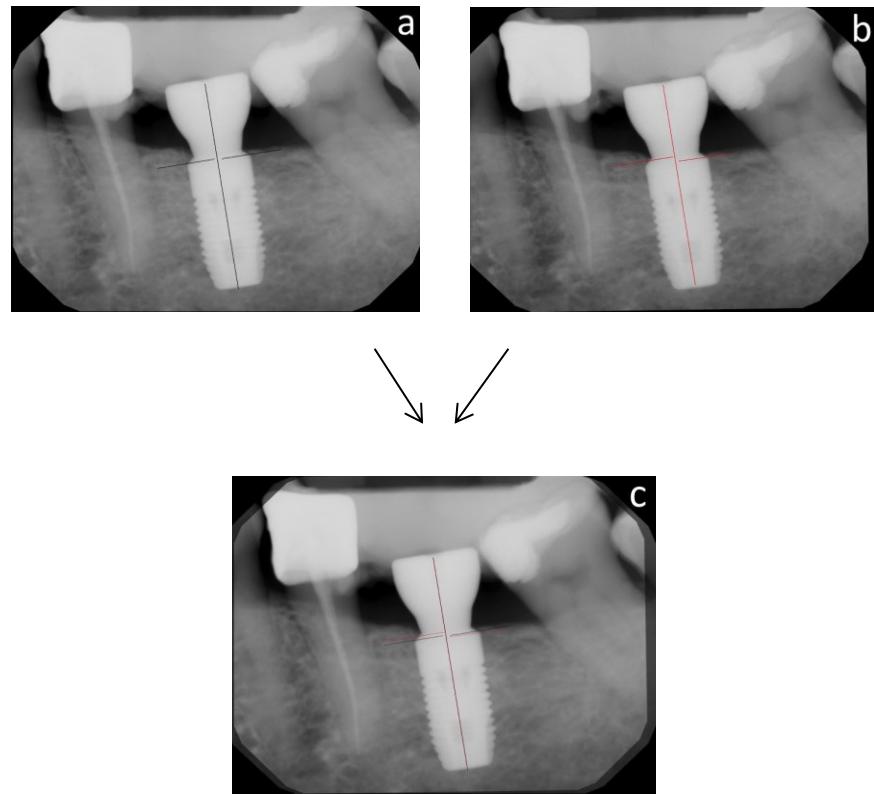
Radiographic evaluation of crestal bone change: a) Baseline periapical radiograph; b) four-month periapical radiograph; c) Superimposed radiographs with baseline and four-month measurements.
